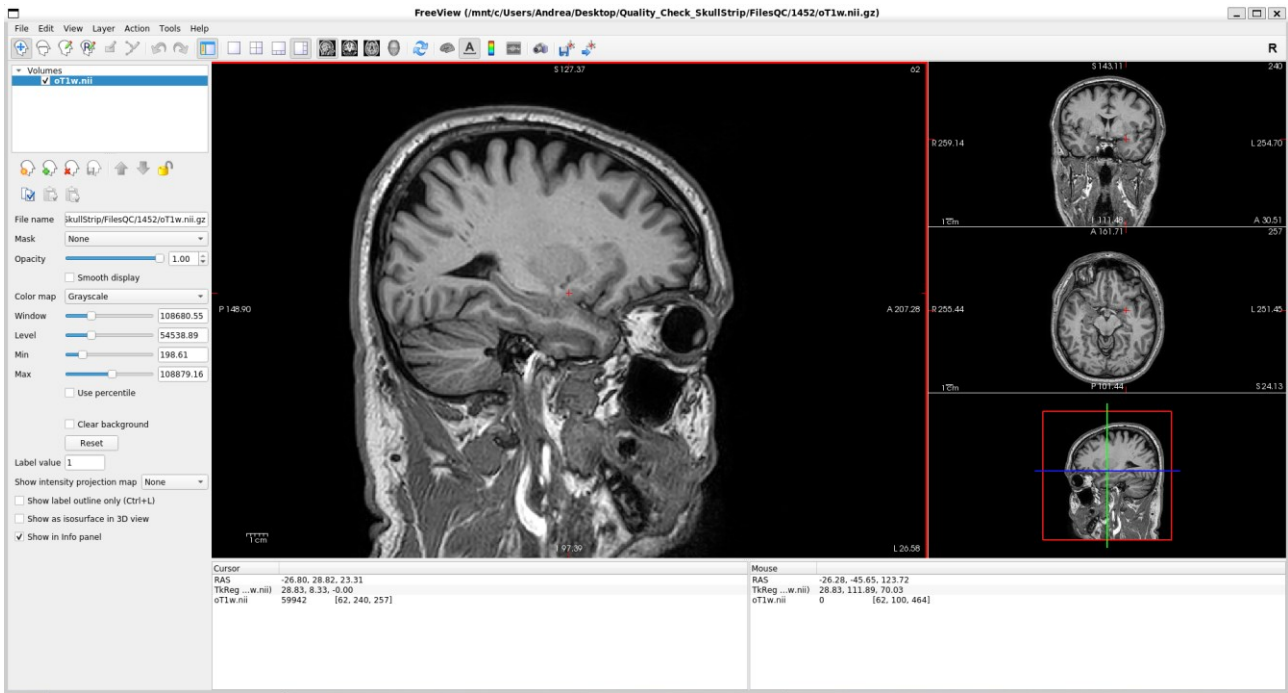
example of the Freeview GUI used to evaluate the quality of structural images, here used to visualize on a three-plane view the T1-weighted image of subject 1452.*
